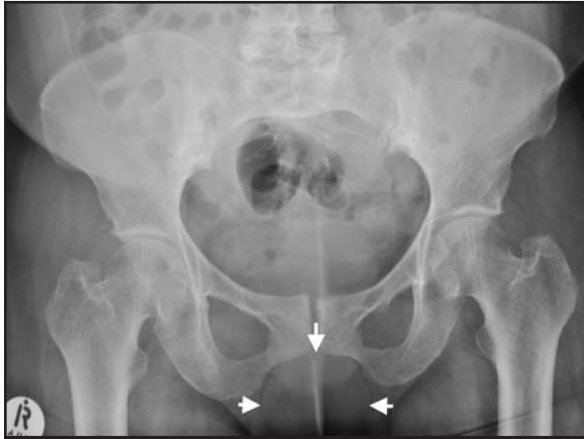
Antero-posterior plain pelvic radiograph shows well-circumscribed soft tissue mass just below the pubic symphysis.
